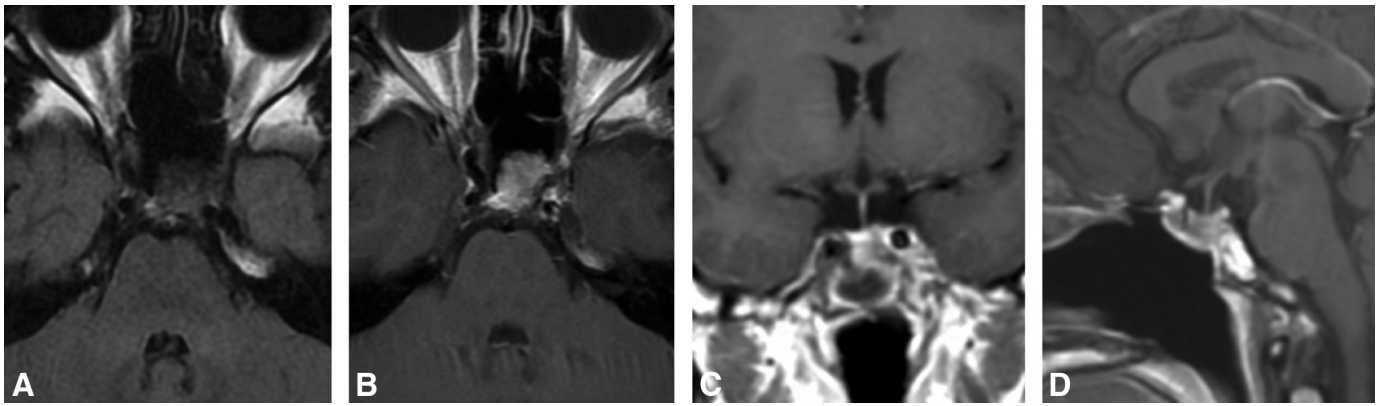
Chordoma. Axial unenhanced T1WI (A); and axial (B), coronal (C), and sagittal (D) postgadolinium T1WI of a chordoma. A 19-year-old man with a history of hypothalamic pituitary dysfunction and growth hormone deficiency. MR imaging demonstrates a lesion into the pituitary sellae, with no contact with the optic chiasm.
